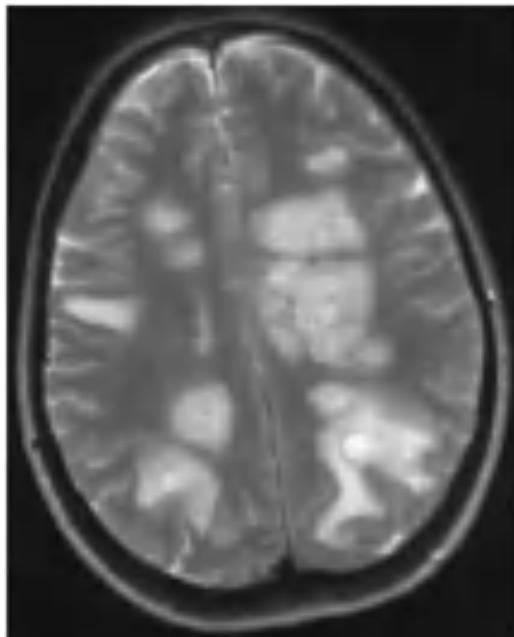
6-year-old patient diagnosed with ADEM presenting with encephalopathy, ataxia, and motor deficits after mild viral infection. Axial T2-weighted MRI shows bilateral, diffuse, poorly demarcated lesions. Gray matter involvement, including the thalamus and basal ganglia, is commonly seen.
